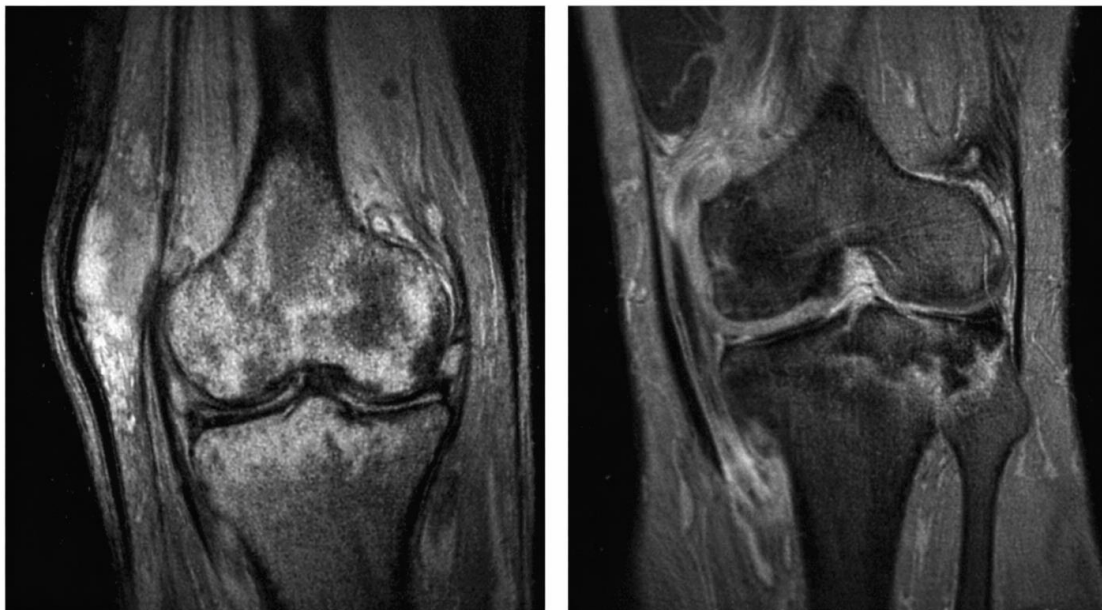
MRI detection of occult fractures and soft tissue injuries in trauma. MRI demonstrates bone marrow edema and associated ligament or cartilage injury, enabling early diagnosis and appropriate intervention.
